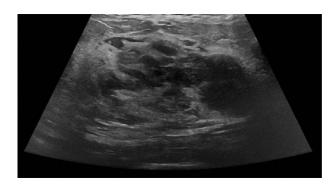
Gray scale ultrasonography of the right breast upper outer quadrant shows a well-defined heterogeneous predominantly solid isoechoic mass lesion with variable sized and shaped cystic areas.
